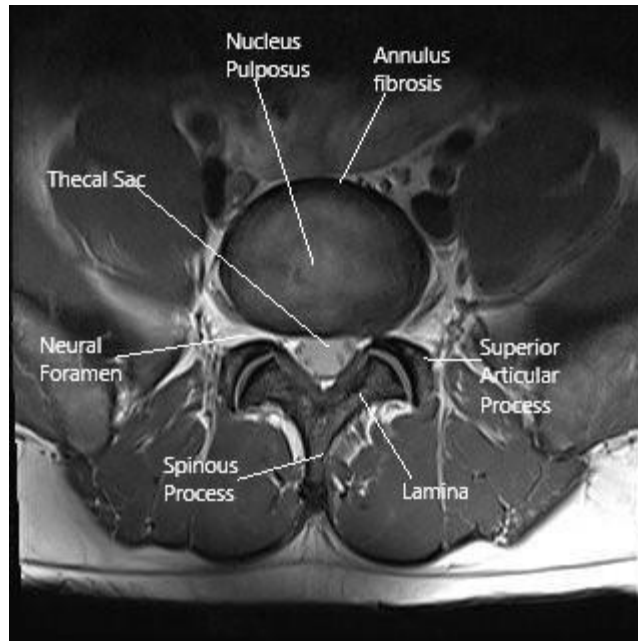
Show normal image of axial T2-weighted MRI scan of lumbar spine (Adam, 2022)
